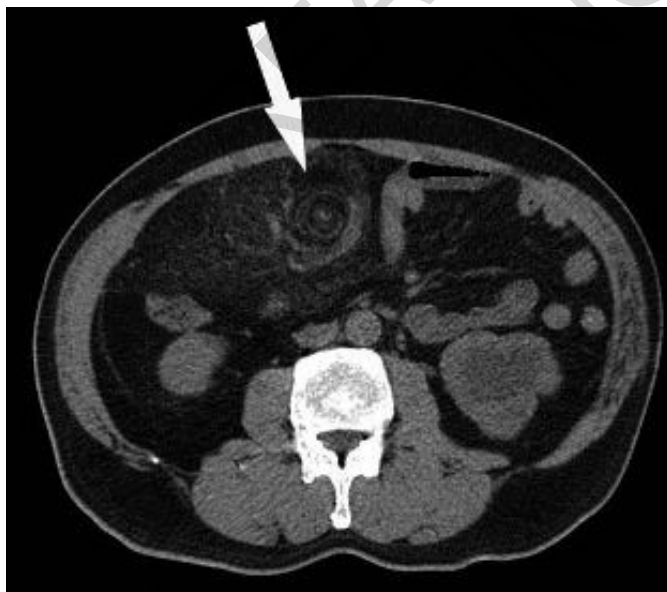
Abdominal CT scan was remarkable for omental stranding with "curvilinear swirling" on the epigastric region, which is the so-called "whirl sign" (white arrow).
